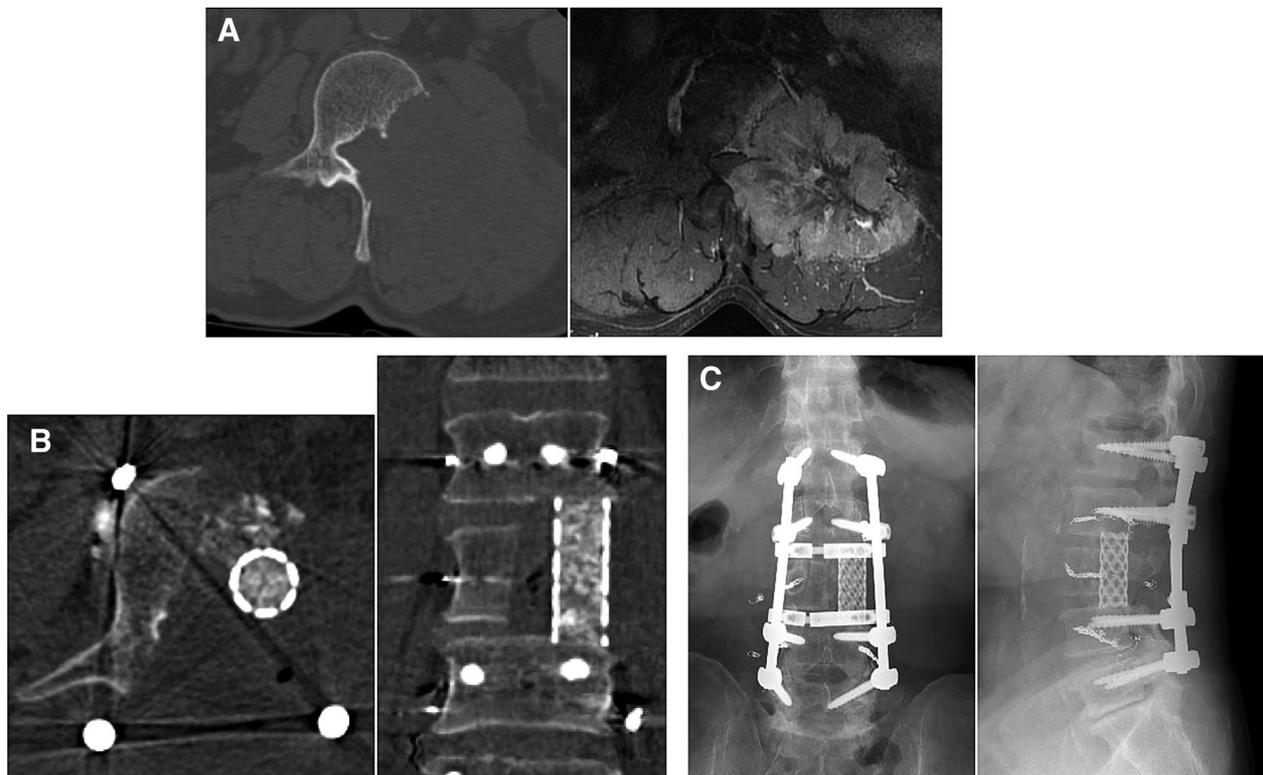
Isolated spinal metastasis from a renal cell carcinoma at L3 in a 65-year-old man. His performance status remained well from the surgery until 4 years later, when he died. There was no tumor recurrence at the operated site. (A): Axial images of computed tomography (left) and magnetic resonance imaging (right) showing the tumor involving the postero-lateral portion of the L3 vertebra, expanding up to the paraspinal muscles. (B): Axial (left) and coronal (right) images of postoperative computed tomography. (C): Anterolateral (left) and lateral (right) views of postoperative radiography.
